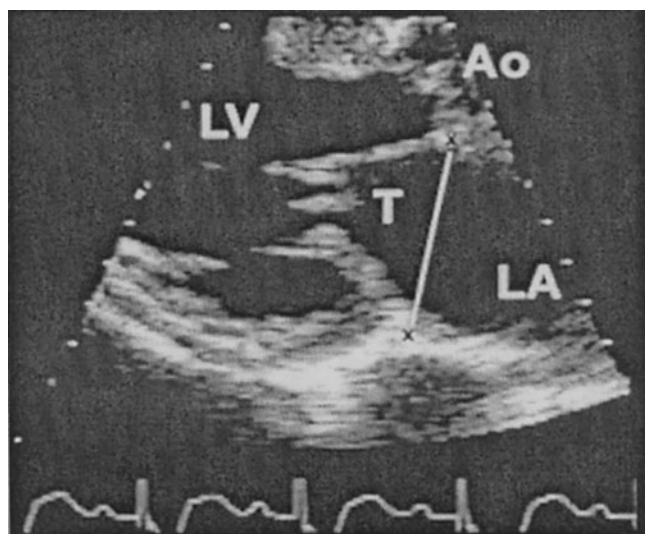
Two-dimensional echocardiography showing the parasternal long-axis view of a patient with functional mitral regurgitation (MR). Note the protrusion of the mitral leaflets toward the left ventricle (LV), resulting in a large tenting area (T) between the leaflets and the annulus (white line with x marking the mitral annulus) and an insufficient coaptation surface available on each leaflet to prevent MR. LA = left atrium; Ao = aorta. (Reproduced with permission of the American Heart Association.)
